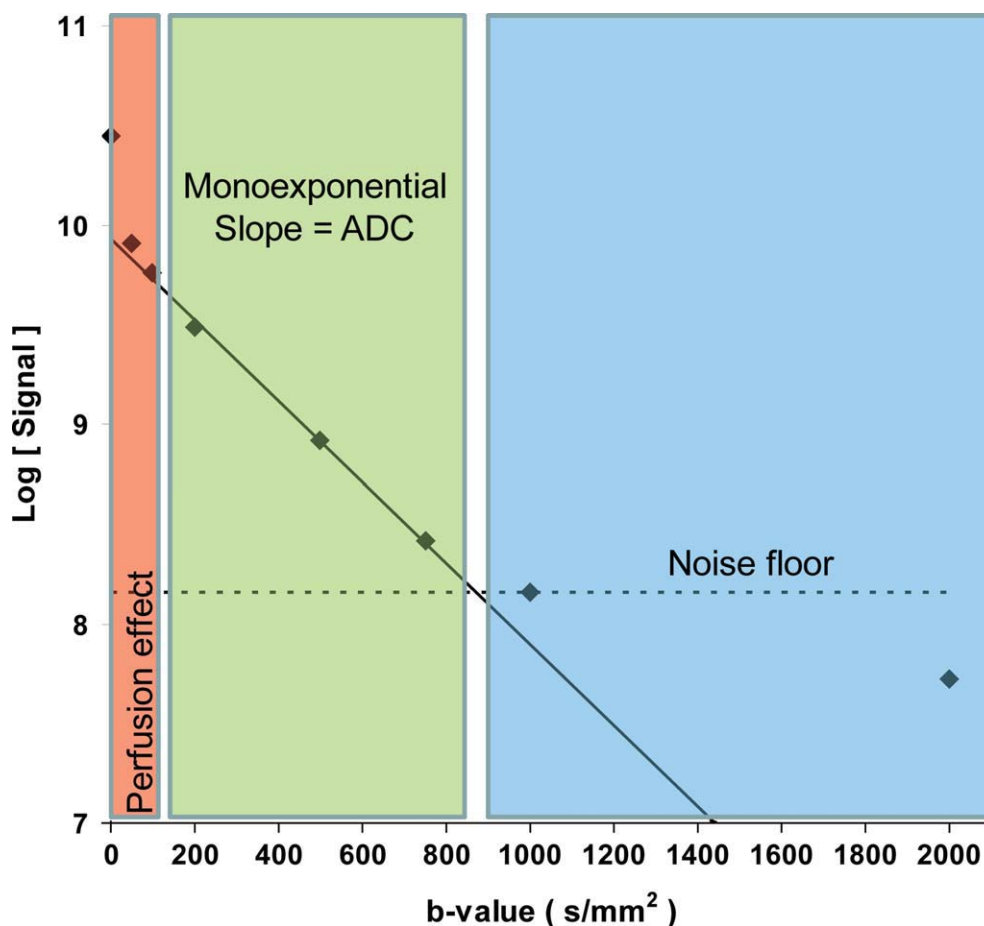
Measured signal decay in kidney cortex of as a function of b-value. Perfusion effect is dominant in the low b-value range (0–100 s/mm²) and would inflate ADC if included in slope calculations. By extinguishing most of the vascular signal at b values greater than 100 s/mm², a true estimate of ADC is derived. Using b-values 100 to 750 s/mm², the estimated kidney ADC = 2.03×10^{-3} mm²/s. The dashed line represents the noise floor. DW-MRI measurements where signal falls within the noise floor lead to erroneous ADC estimates and a false multi-exponential appearance to the log(signal) versus b-value curve. Tissues do exhibit true multi-exponential diffusion decays over a wide b-value range (b = 500 to > 3000 s/mm²), although very high SNR is required to document these features. [Color figure can be viewed in the online issue, which is available at www.interscience.wiley.com.]
